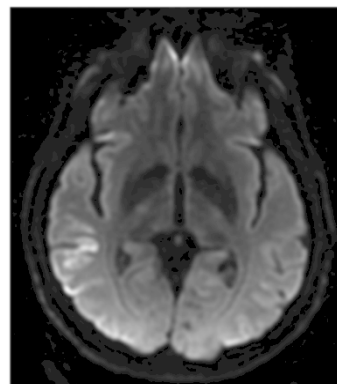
Diffusion-weighted image from the MRI performed in June, 2013, showing hyperintensity of the right basal temporo-occipital cortex (3 Tesla scan)
